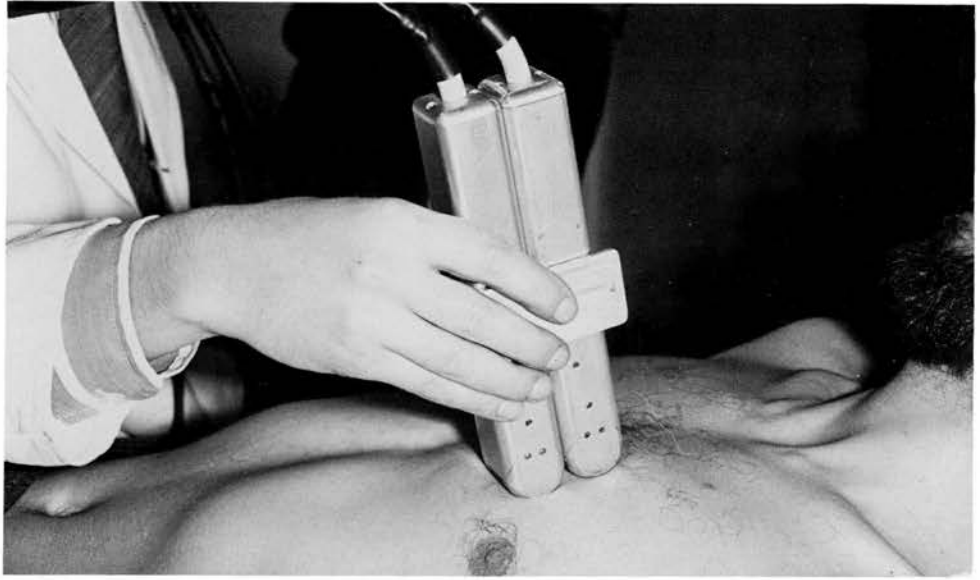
Twin scanners applied at adjacent intercostal spaces and unrelated at the parasternal and subxiphoid locations.
